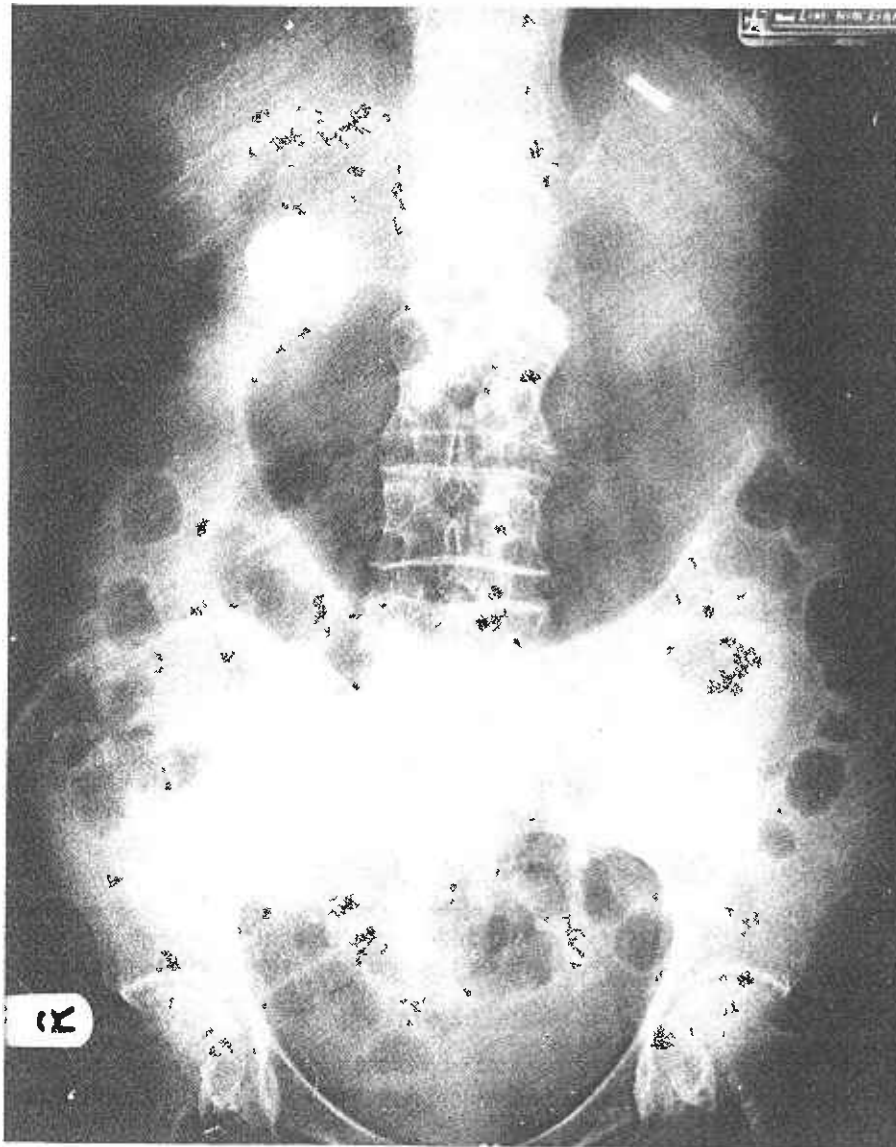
Plain abdominal X-ray showing a dilated stomach and calcified gallstone.
